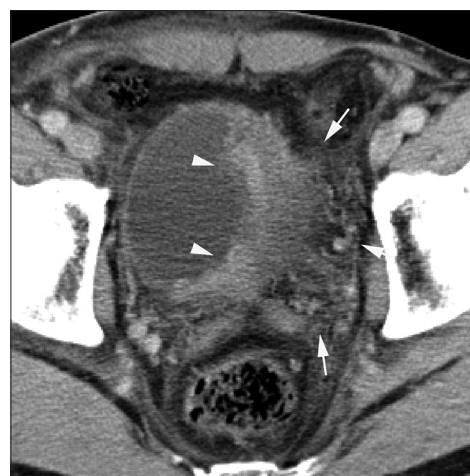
Postcontrasted CT image revealing an irregular thickening of the left side of the bladder wall (arrowheads) and a stranding of a surrounding fat tissue (arrows)
